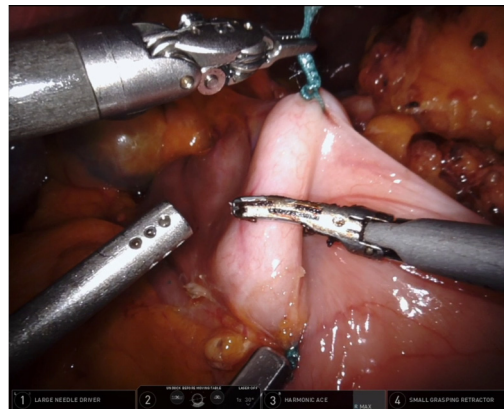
Pyloromyotomy is performed by dividing the pylorus longitudinally along its entire length with the ultrasonic scalpel. Note the “12 o’clock” and “6 o’clock” orientation of the pylorus created by traction on the lateral stay sutures.
